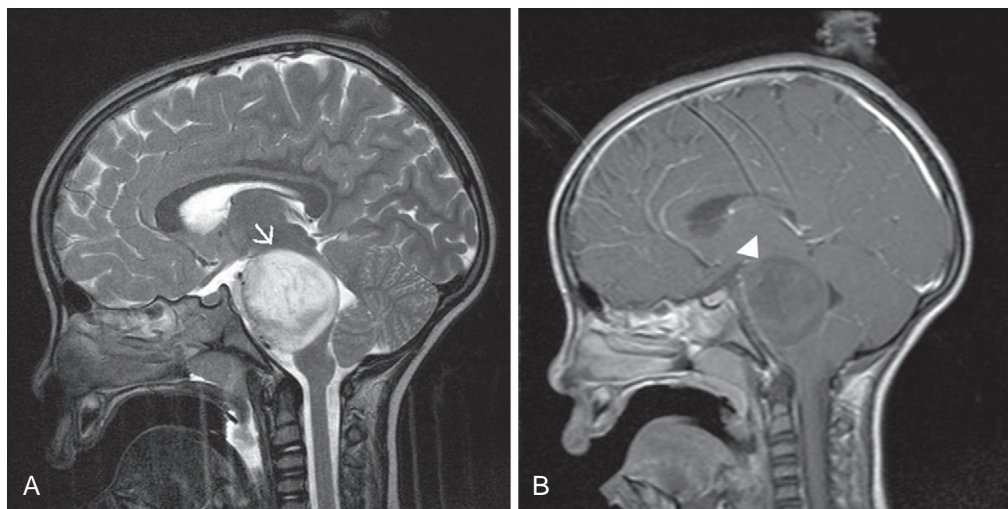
A, Sagittal T2WI image in a 4-year-old girl showing an infiltrative, hyperintense tumor in the pons (white arrow). B, Sagittal T1WI postgadolinium image showing that the tumor does not enhance (white arrowhead). This tumor is an intrinsic pontine glioma, and the diagnosis is made by MRI alone, a biopsy is not required.
